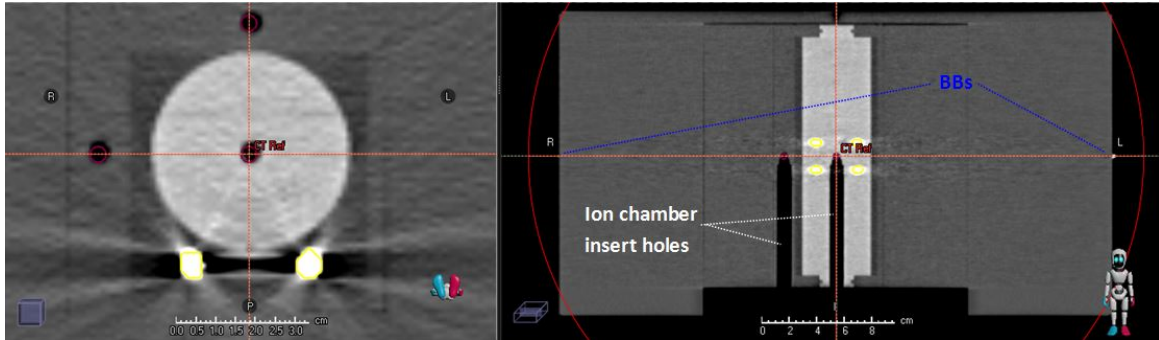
A large diameter POI (labelled CT Ref) placed on CT scans imported into RayStation of MattL with BBs taped onto MattL's external markings which coincides with MattL's geometric centre. The POI was aligned to intersect the external BBs and intersected the location of the active volume of an ionisation chamber, when inserted into the ionisation chamber holes (maroon circles).
